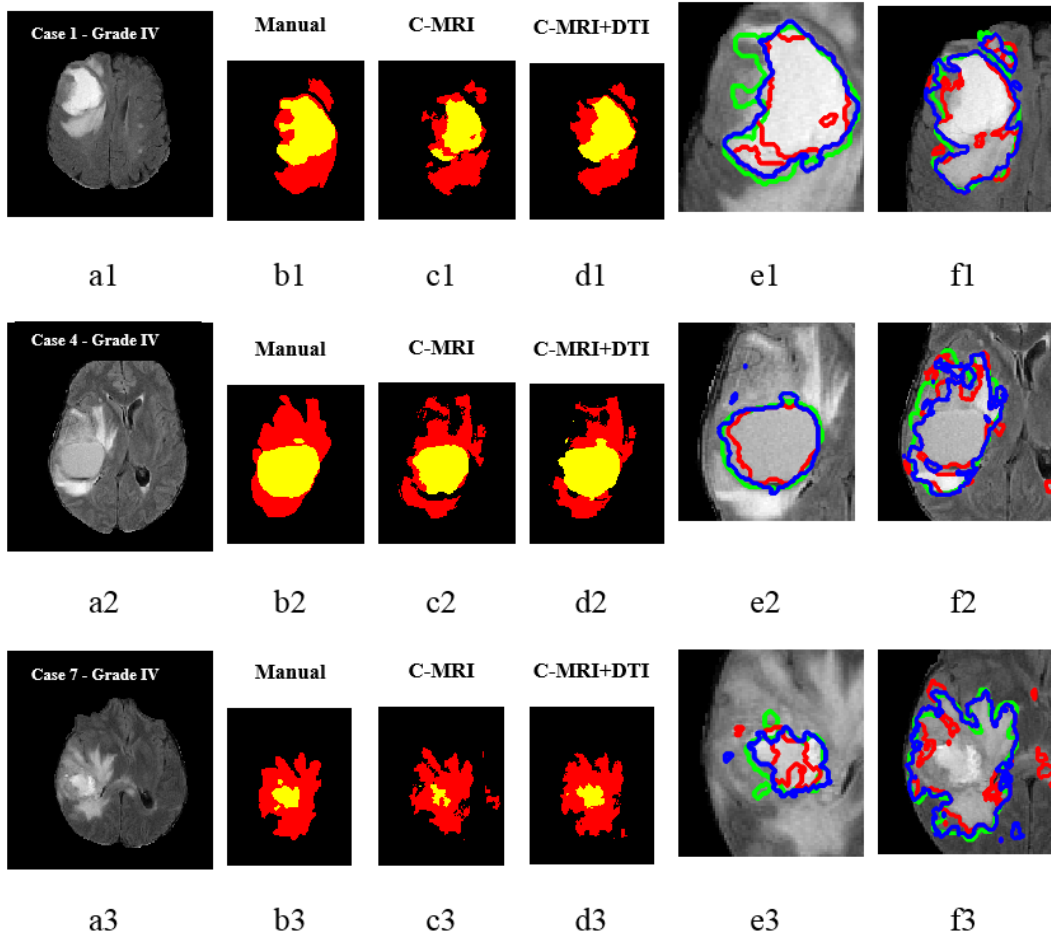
Comparison examples of segmentation of tumour core and oedema using conventional MRI and conventional MRI plus DTI for three different cases with grade IV tumours. A) FLAIR image, B) manual segmentation of core (yellow region) and oedema (red region) C) segmentation using conventional MRI, D) segmentation using conventional MRI and DTI (M-MRI), E) comparison of both methods C-MRI (red), plus DTI (blue) and manual (green) segmentation for core (zoomed in), F) comparison of both methods C-MRI (red), plus DTI (blue) and manual (green) segmentation for oedema (zoomed in)
